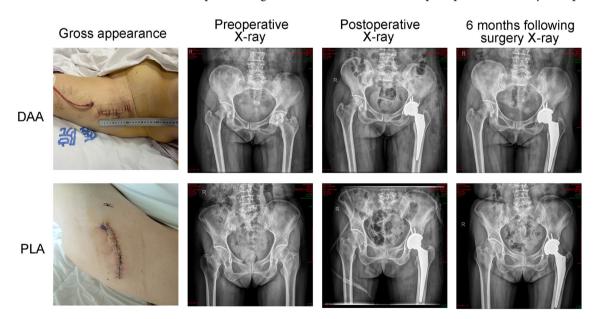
Comparison of postoperative gross appearance and X-ray images between patients who underwent the direct anterior approach (DAA) and posterolateral approach (PLA) for total hip arthroplasty (THA)
